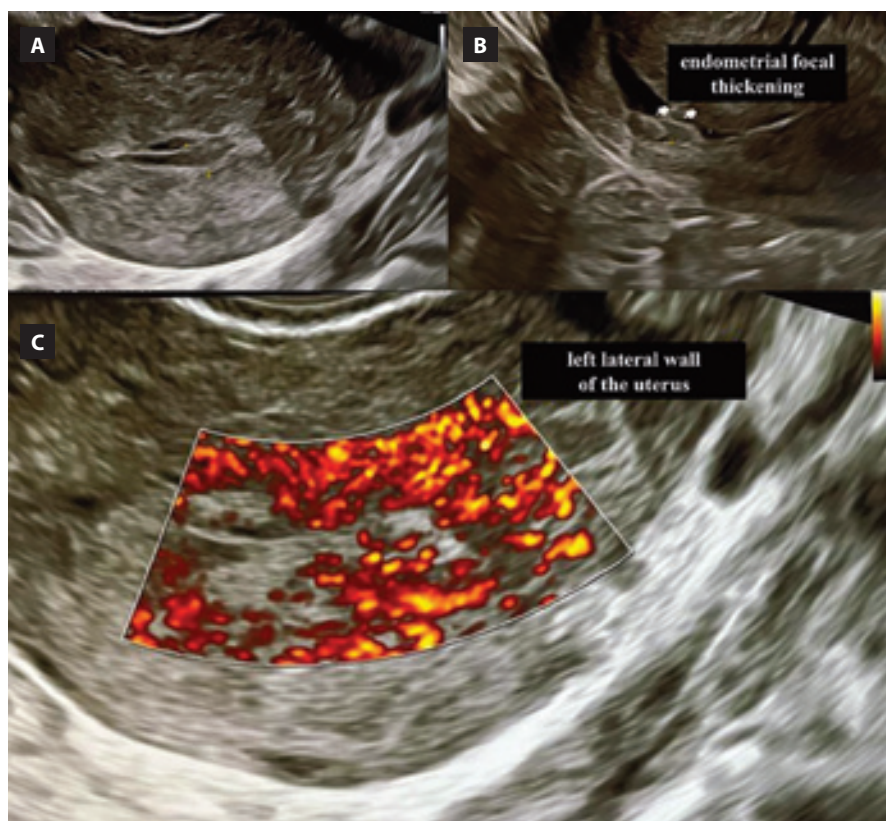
Pelvic-transvaginal ultrasound, showing focal, heterogeneous endometrial thickening in the left cornual uterine region (A and B), followed by exuberant myometrial vascularization in this topography (C).
